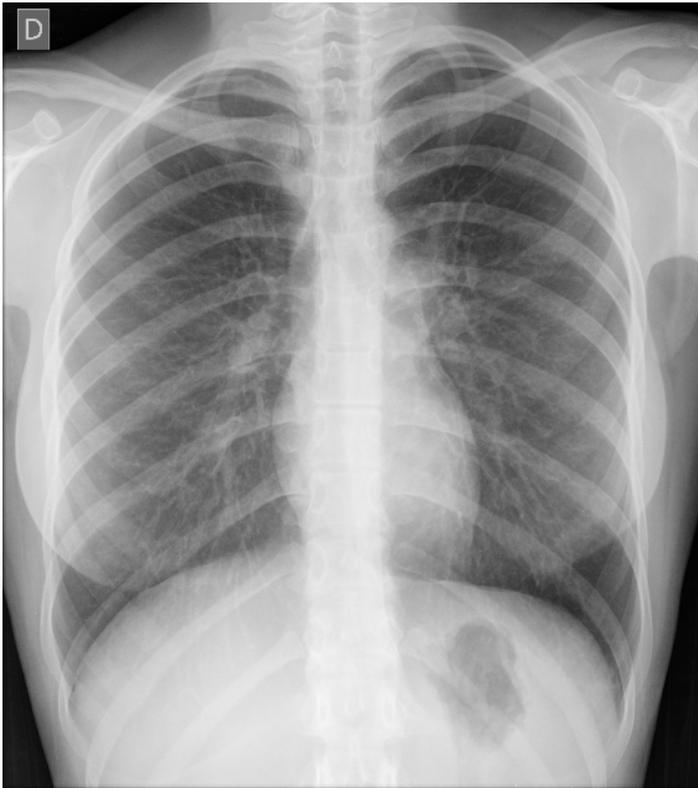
The patient had a normal chest radiograph at her first consult.
